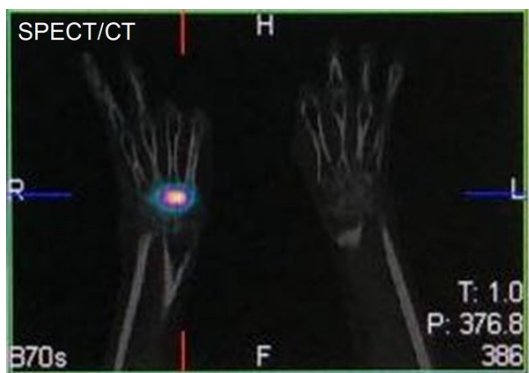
A 56-year-old male patient with rheumatoid arthritis of wrist joint. SPECT/CT image 24 h post-administration of 222 MBq of ^{177}Lu -HA.
